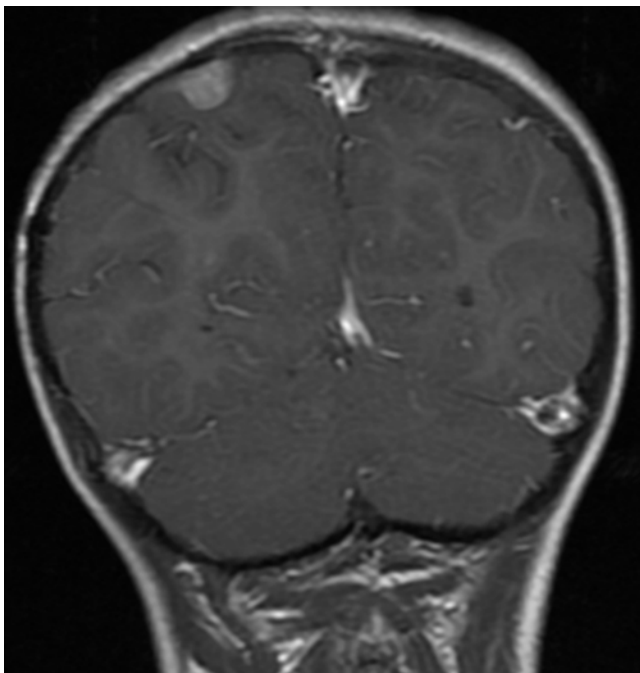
Coronal T1-weighted MR imaging with contrast enhancement showing an extraaxial ependymoma that mimicked meningioma on imaging.
